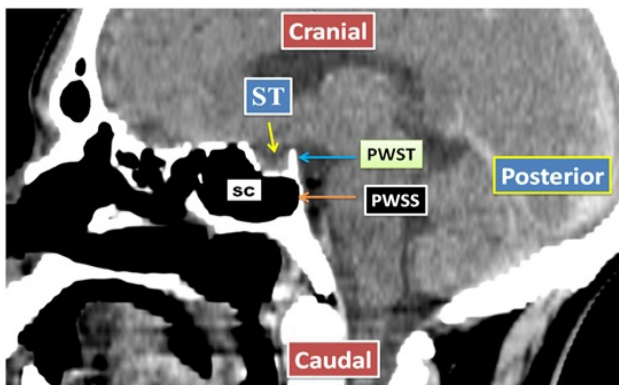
A sagittal CT Slide of Sphenoid Sinus of a 67-year-old female showing Postsellar Pneumatization. ST = Sellar Turcica, PWST = Posterior Wall of Sellar Turcica, PWSS = Posterior Wall of Sphenoid Sinus, SC = Sinus Cavity
